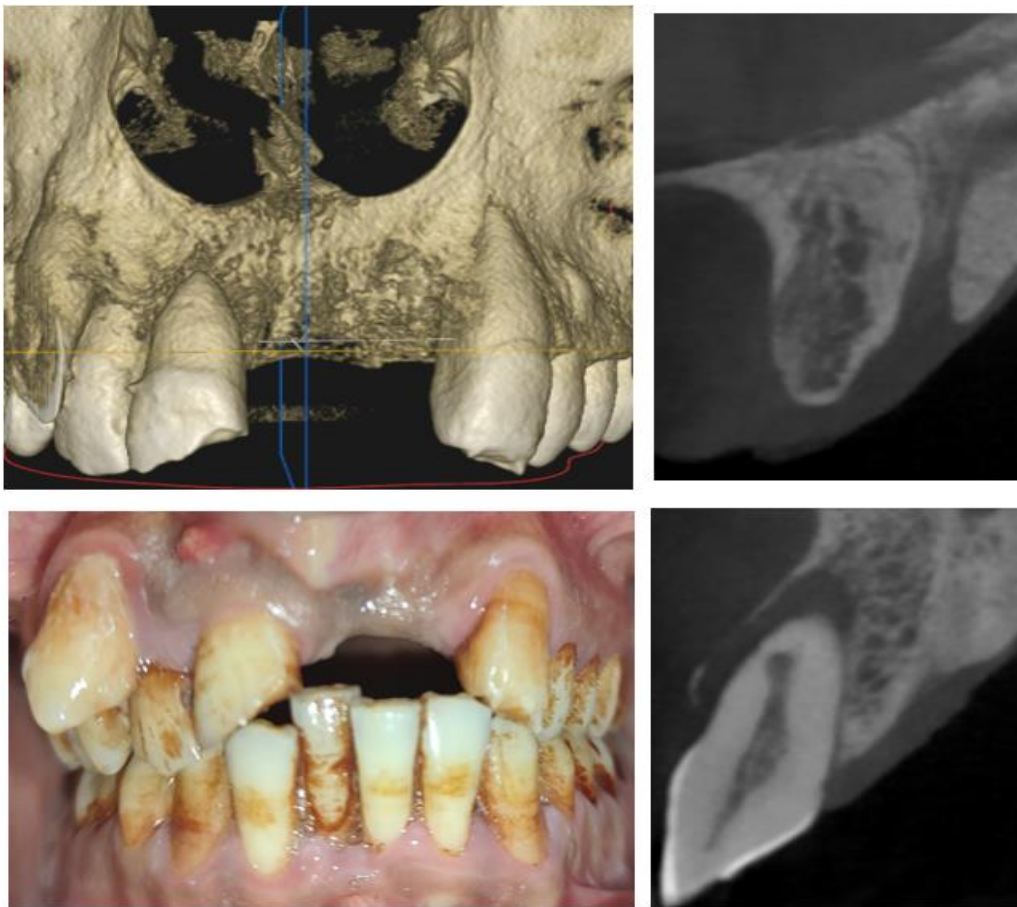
Pre-Operative CBCT and Intra-Oral photographs.
